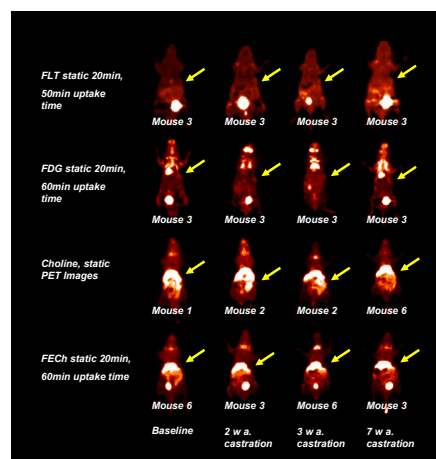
Shows static PET Images for [¹⁸F]FLT, [¹⁸F]FDG, [¹¹C]Choline and [¹⁸F]FECh for the PAC120 tumour model.
